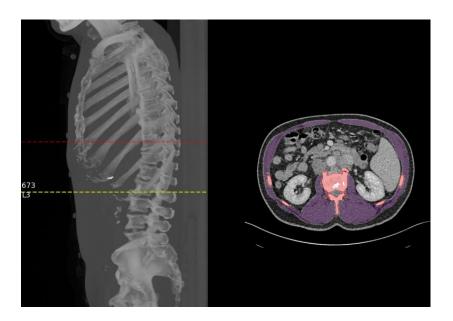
example of CT mask showing muscle mass delineated in purple at L3 level, and bone delineated in red.
